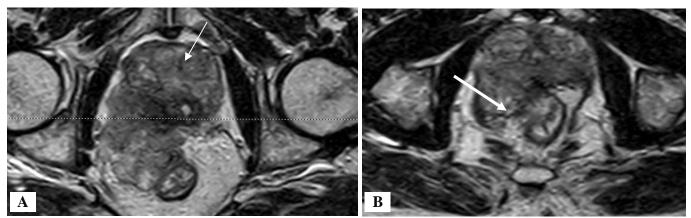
Axial MRI T2 weighted images pre-radiation of a case of metastatic hormonal-sensitive prostate cancer.
